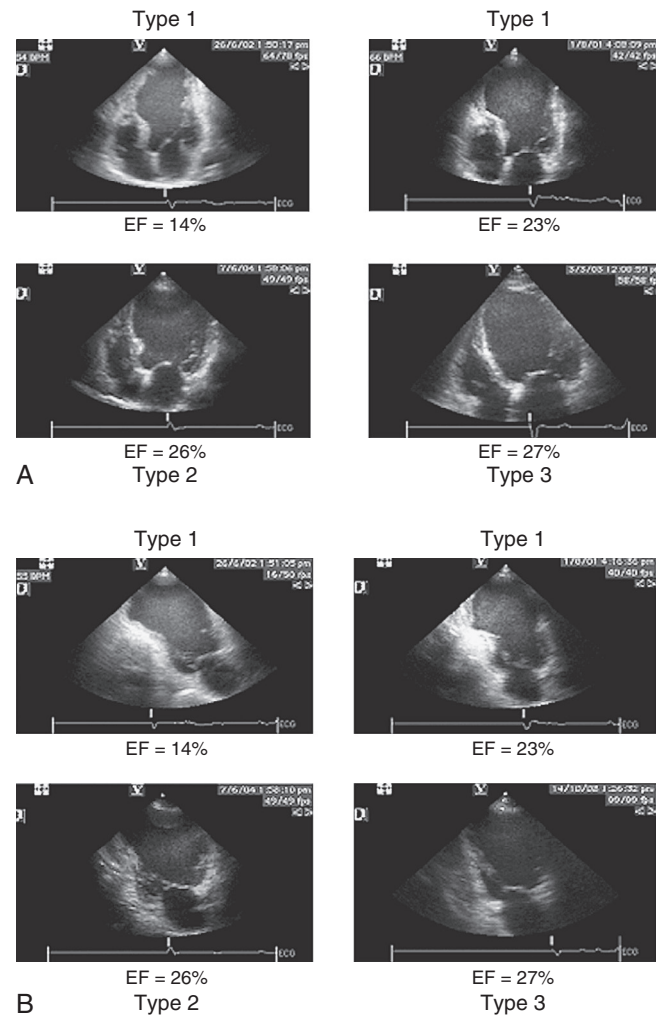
■ Echocardiographic four-chamber (A) and two-chamber (B) views are shown in four patients after an anterior myocardial infarction. All patients have marked left ventricular dilation with low ejection fraction (EF), but the shapes are definitely different. Types 1, 2, and 3 are shown.
